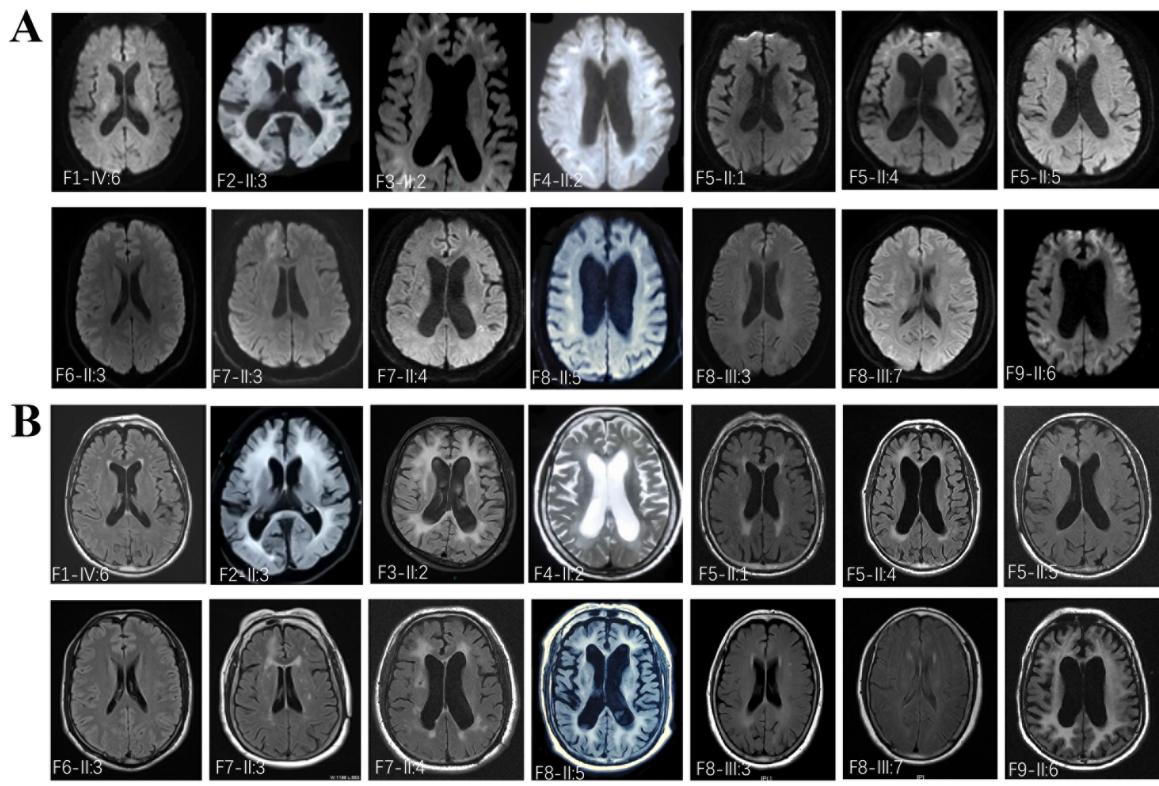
MRI Imaging of NIID. (A) DWI images of some NIID-affected case subjects revealed typical symmetrical high signal in corticomedullary junction. (B) Several NIID-affected case subjects showed severe white matter hyperintensity using FLAIR or T2 weighted image.
